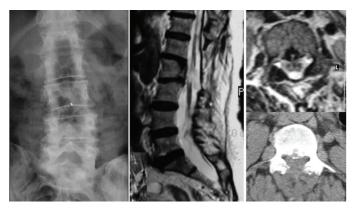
At 12 months follow-up, she returned to her job, she reported complete resolution of her back and legs symptoms but incontinence continues. MR and CT shows bone spur removal and no tethering of spinal cord
